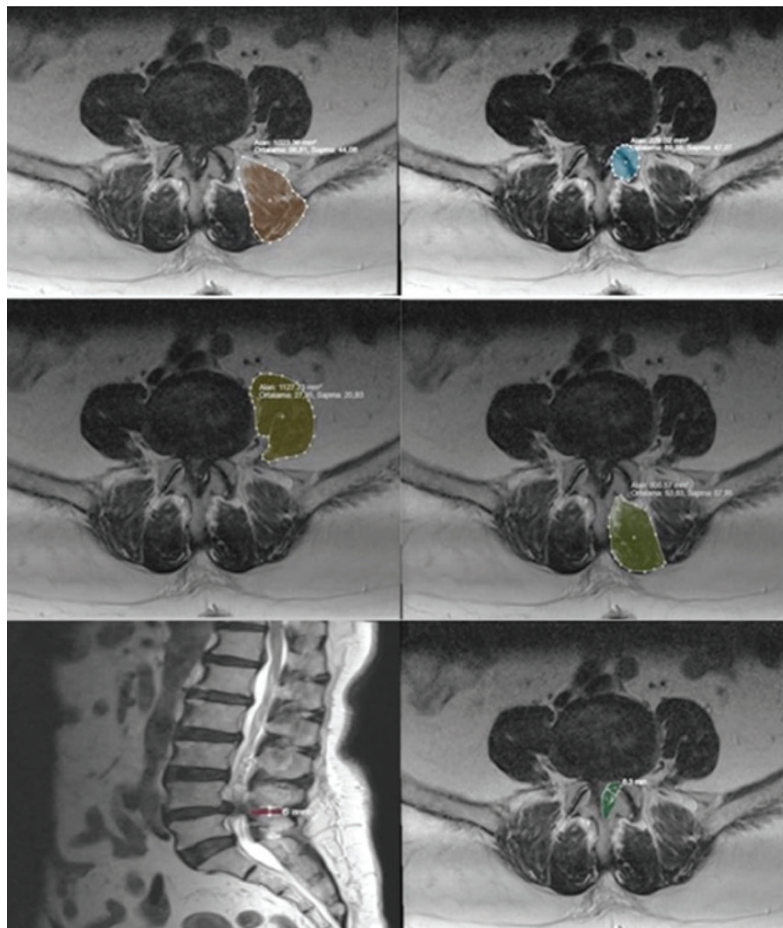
Measurement of interspinous ligament and ligamentum flavum thickness, facet joint, multifidus, erector spinae and psoas muscle areas in sagittal and axial lumbar MRI sections
